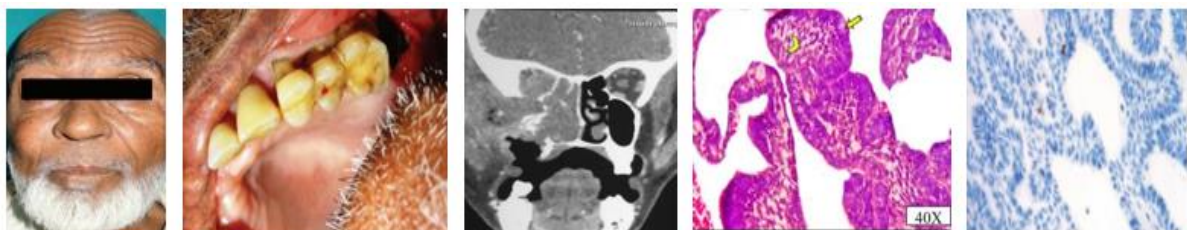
(a) Extraoral photograph (b) Intraoral photograph showing swelling left upper buccal vestibular region with 25,26 (c) Computed tomogram (coronal view) shows a well-defined osteolytic lesion (d) H & E (40x) (e) Calretinin negative
